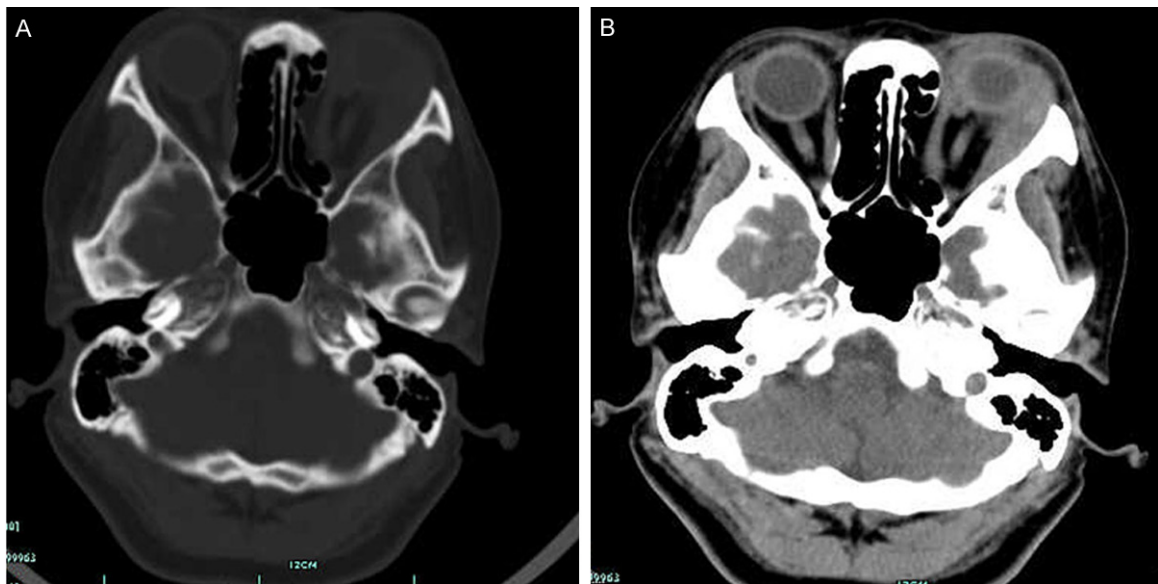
CT showed an irregular mass in the left orbit involving the left superior rectus, external rectus, and inferior oblique and medial rectus muscles (A). (B) Contrast-enhanced imaging showed that the tumor was enhanced markedly.
